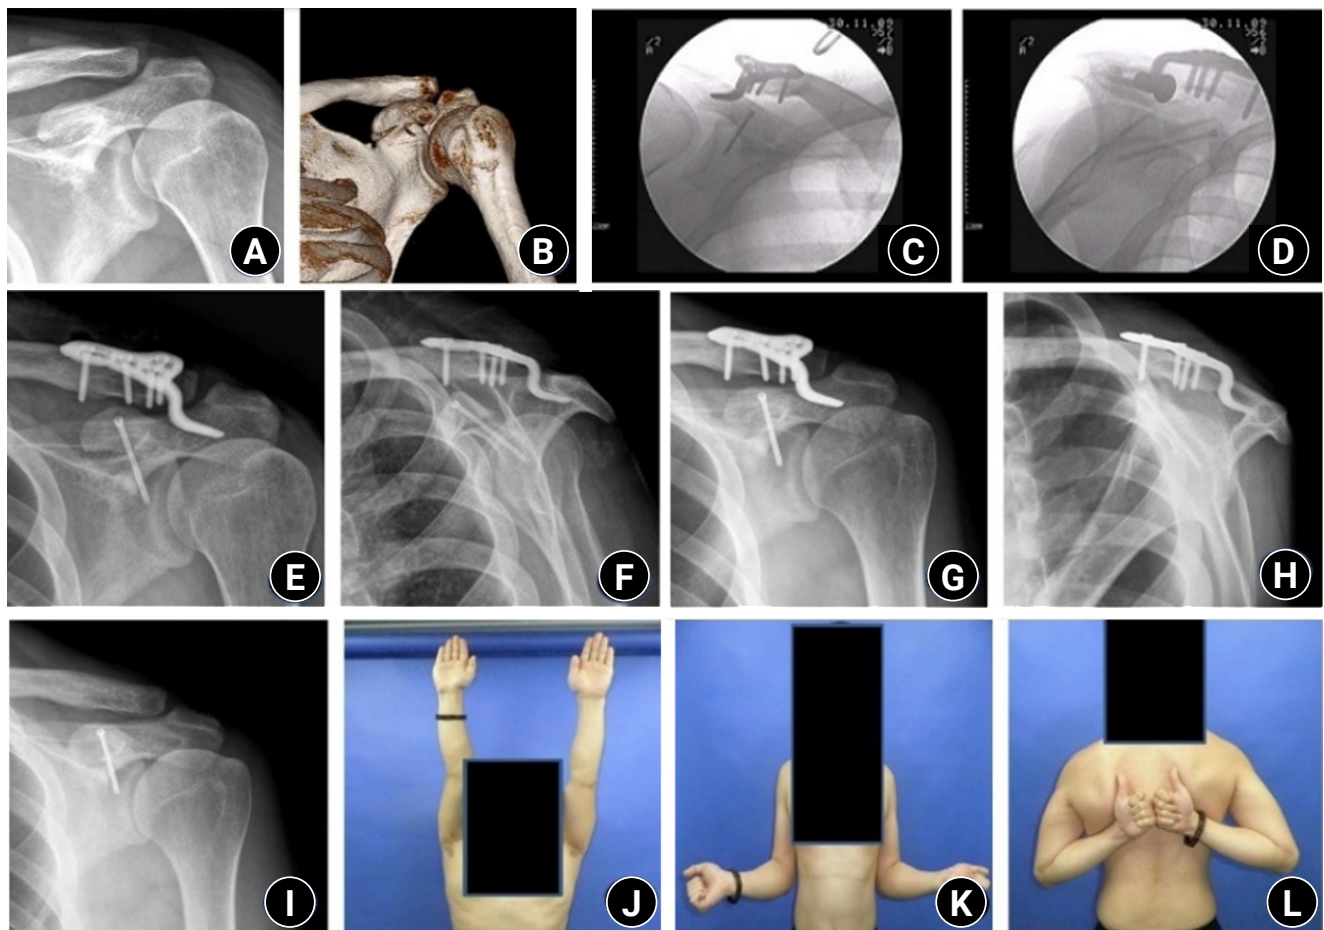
(A, B) Initial shoulder anteroposterior (AP) radiograph and three-dimensional computed tomography images of a 33-year-old male patient show a coracoid process fracture associated with an acromioclavicular joint (ACJ) injury. (C, D) Immediate postoperative C-arm images demonstrate open reduction and internal fixation using a 3.0-mm headless compression screw (HCS) for the coracoid process fracture and a clavicle hook plate for the ACJ injury. (E, F) Immediate postoperative shoulder AP and scapular Y radiographs show fixation using a 3.0-mm HCS for the coracoid process and a clavicle hook plate for the ACJ injury. (G, H) Postoperative 2-month AP and scapular Y radiographs show union of the coracoid process. (I–L) At the final follow-up, the patient demonstrated satisfactory radiographic and clinical outcomes, including full active range of motion.
